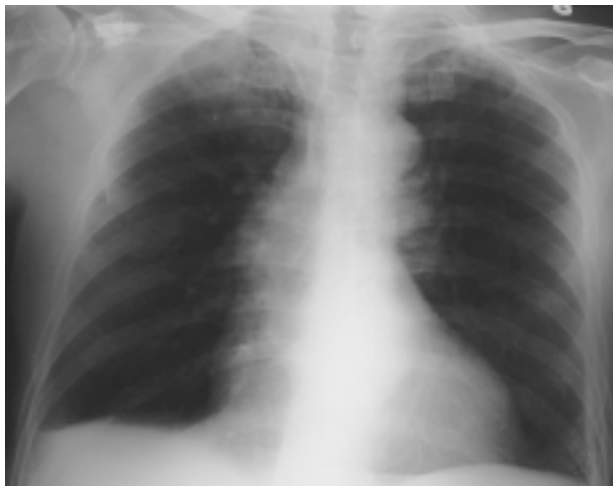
Pulmonary radiograph of right subclavian catheterization control.
